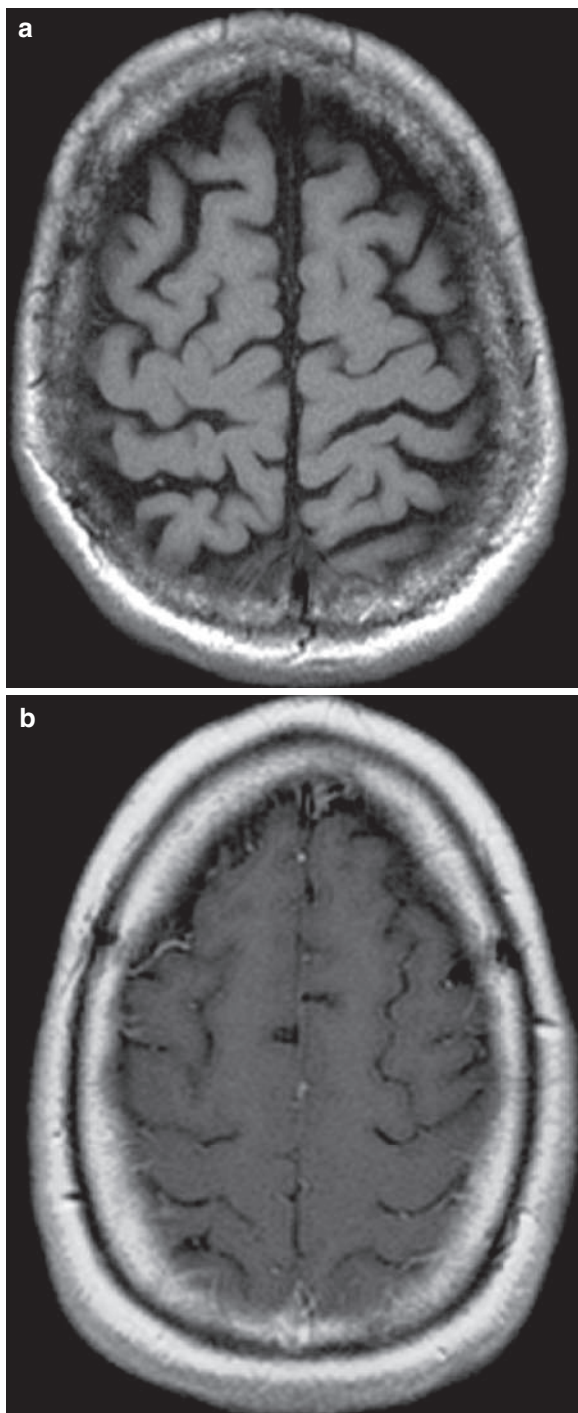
Two different patients with T1W image MRI of the brain. In image (a), there is marked bone resorption of the inner surface of the skull in a patient with prolonged primary hyperparathyroidism (salt and pepper skull appearance). Compare the skull bones with the normal skull in image (b)
